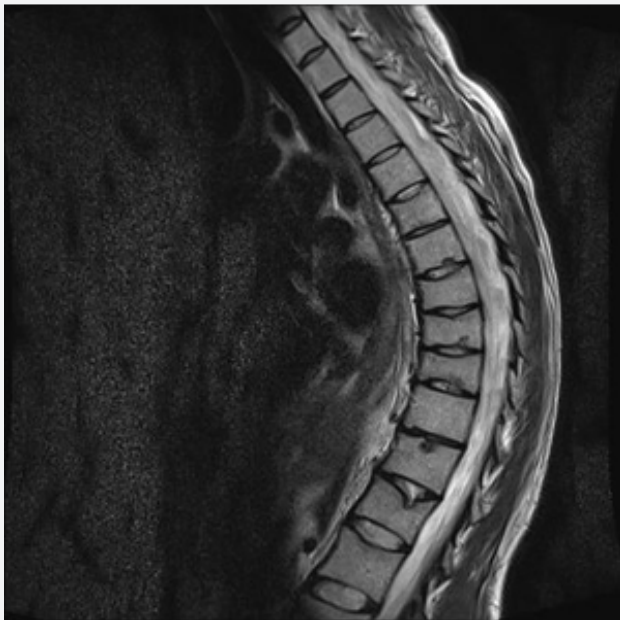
T1 sagittal magnetic resonance imaging at the end of two years
